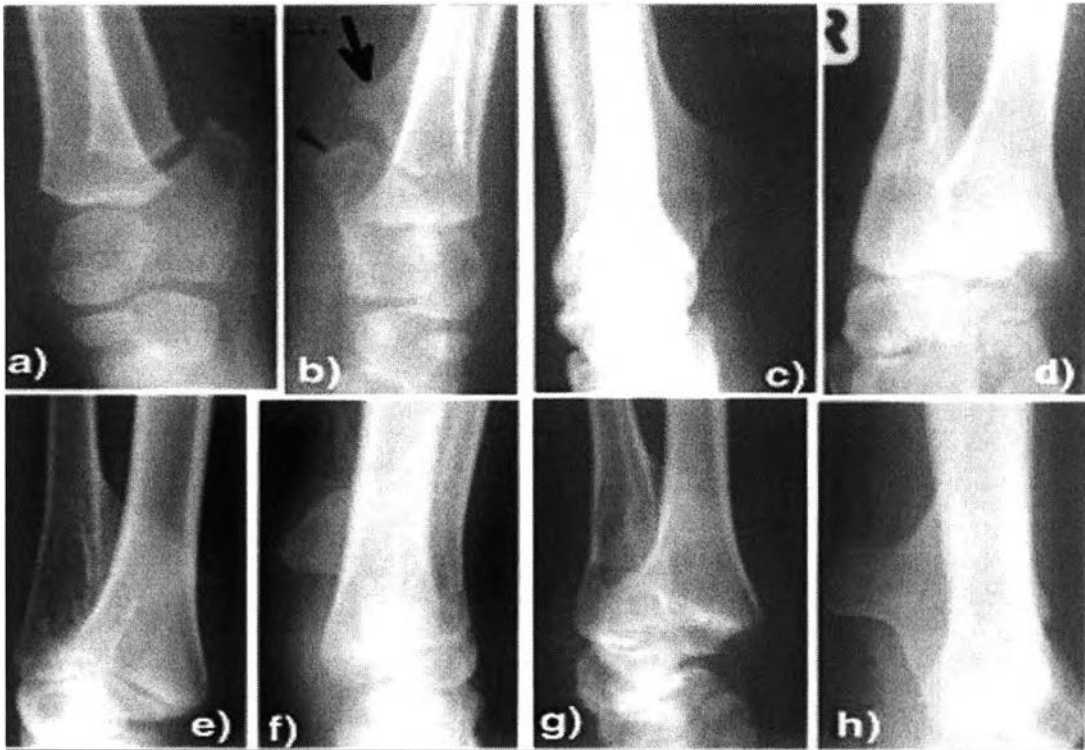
Ankle radiographs of (a) Patient V1. Right ankle. Note vertical positioned calcaneus. No fibular prominence. b: Patient V1. Left ankle. Note fibular prominence (arrow). Malformed and separate calcaneus (arrow head). Fibular prominences in Patients (c) IV2, (d) IV7, (e) IV6, (f) III11, (g) III7, (h) III17.
